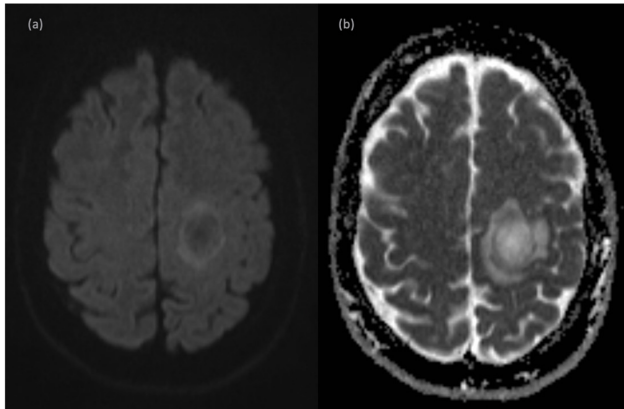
DWI (a) and ADC map (b) demonstrate restricted diffusion only in the periphery of the lesion reflecting the inflammatory cell infiltrates.
